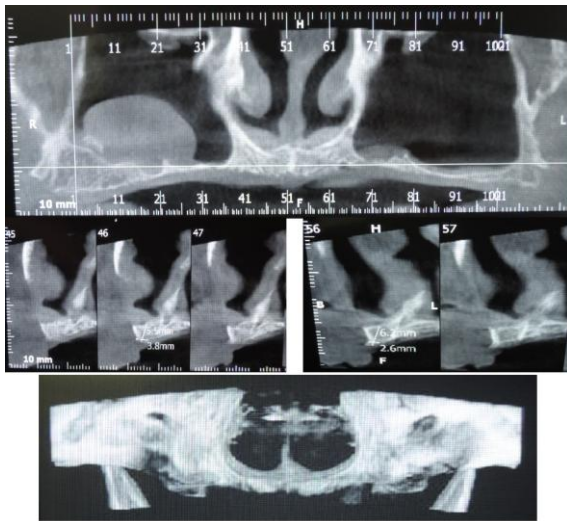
CT images of patient's maxilla
